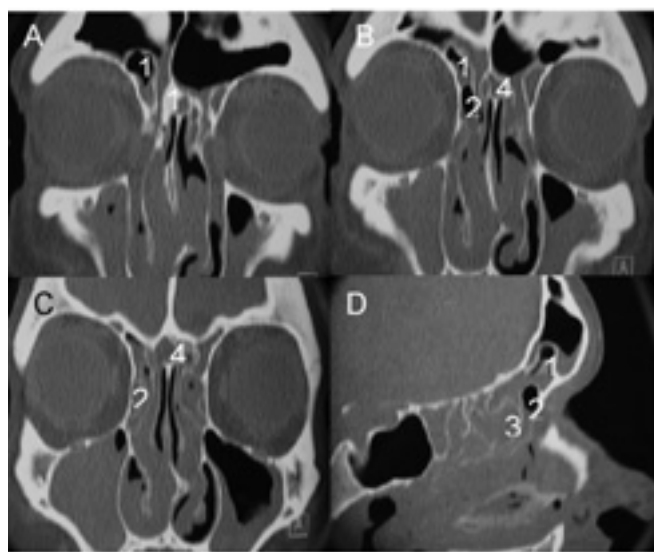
CT scans A, B and C are sequential coronal CT scans. Scan D is a right sided parasagittal scan and therefore the right side is assessed. Cell number 1 (K3 as it protrudes into the frontal sinus) is seen on the coronal scan and identified on the parasagittal scan. Cell number 2 (aggrer nasi cell) and cell number 3 (bulla ethmoidalis) are also identified in both coronal and parasagittal scans. Cell number 4 (intersinus septal cell) is seen on the coronal but not the parasagittal as the parasagittal cut is lateral to the cell.
